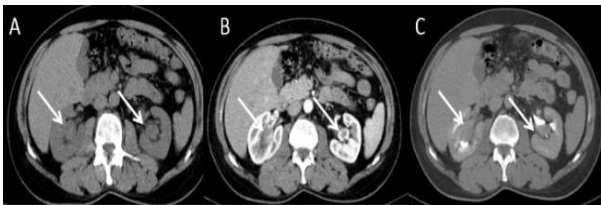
Axial Computerized Tomography (CT) Scan Without Contrast
